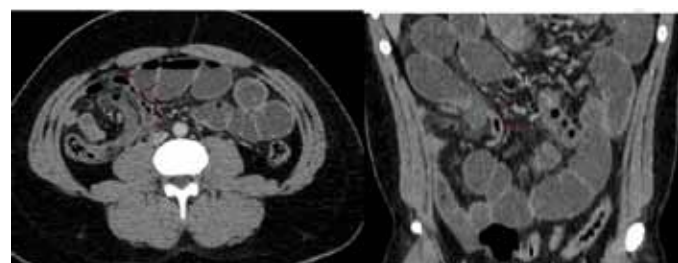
Contrast enhanced computed tomography scan of abdomen: (A) Axial, (B) coronal reformats showing Meckel's diverticulum as non-dilated air and fluid filled short loop in between the dilated fluid filled small bowel loops. There is crescent shaped localized fluid collection with air fluid level and no marginal enhancement adjacent to diverticulum denoting localized perforation.
